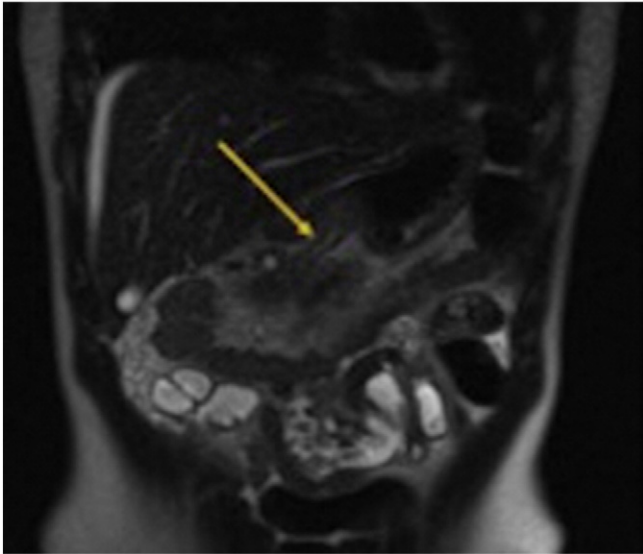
Coronal T2-weighted single-shot turbo spin-echo image shows pancreatic parenchyma (arrow) more ventral than the expected location of normal pancreas. Not shown, the accessory pancreatic lobe and normal pancreas are continuous with each other on contiguous slices.
